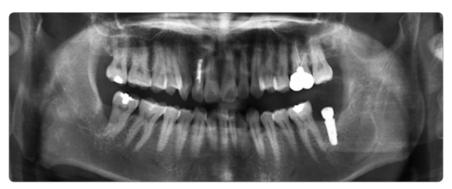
Post-op radiography
